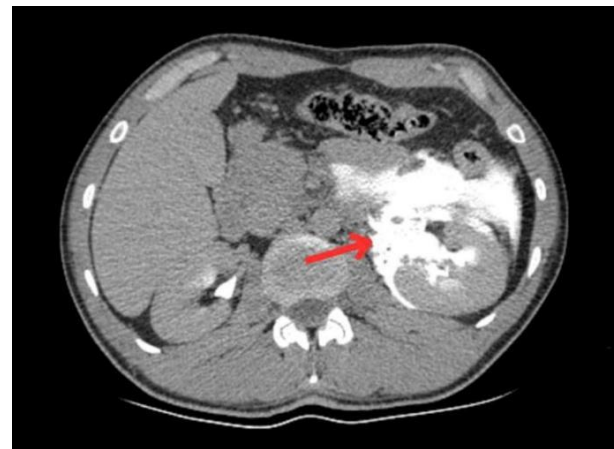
Axial image of the contrast-enhanced CT scan in the delayed phase showing contrast extravasation (arrow).
